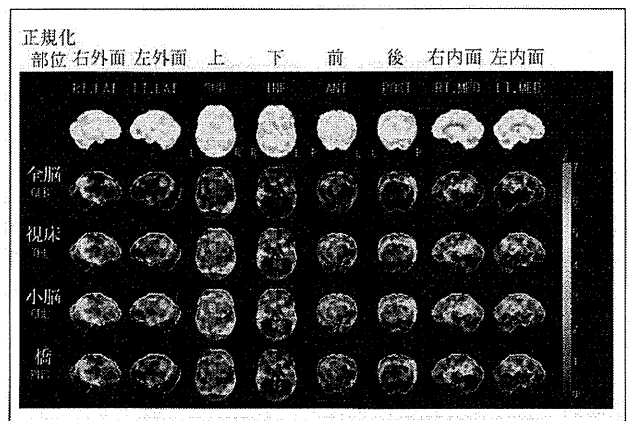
3D-SSPによるアルツハイマー病患者のSPECT画像の処理結果
